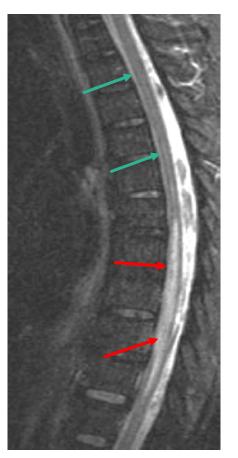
Spinal cord infarction demonstrating cord swelling and increased signal (red arrows) on a sagittal T2-weighted image. Areas without spinal cord infarction (green arrows)
